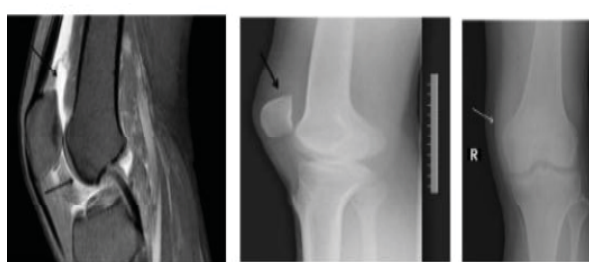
(a) MRI showing knee joint effusion in a 48 year old female patient which appears as hyperintense areas (arrows) on T2 image (b) plain radiograph showing fullness/ increased density in the supra patellar region on lateral projection (arrow) and (c) lateral displacement of the soft tissues at the tibio femoral joint on AP view of a 40 year old female patient (area of increased density shown by an arrow)
